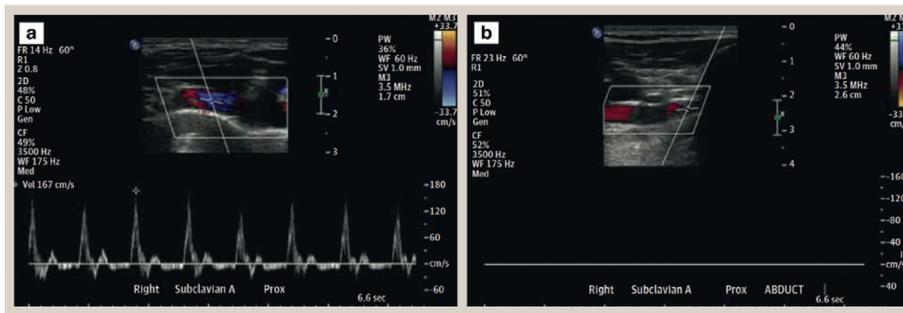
Duplex ultrasonography demonstrating cessation of arterial flow in stress positioning with arm abduction.
